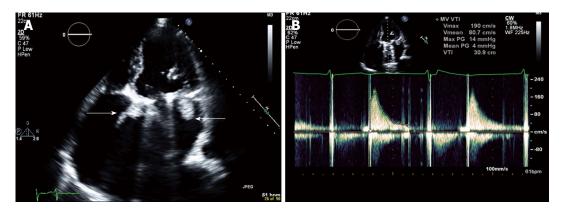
Prosthetic mitral valve thrombosis. A: Transthoracic two-dimensional echocardiogram in apical four-chamber view; B: Transthoracic continuous wave Doppler across mitral valve. Bi-leaflet prosthetic mitral valve seen with echo density, suggestive of thrombus, attached to the atrial side of the bi-leaflet prosthetic mitral valve. The maximum peak gradient across the prosthetic mitral valve is 14 mmHg and mean peak gradient 4 mmHg.
